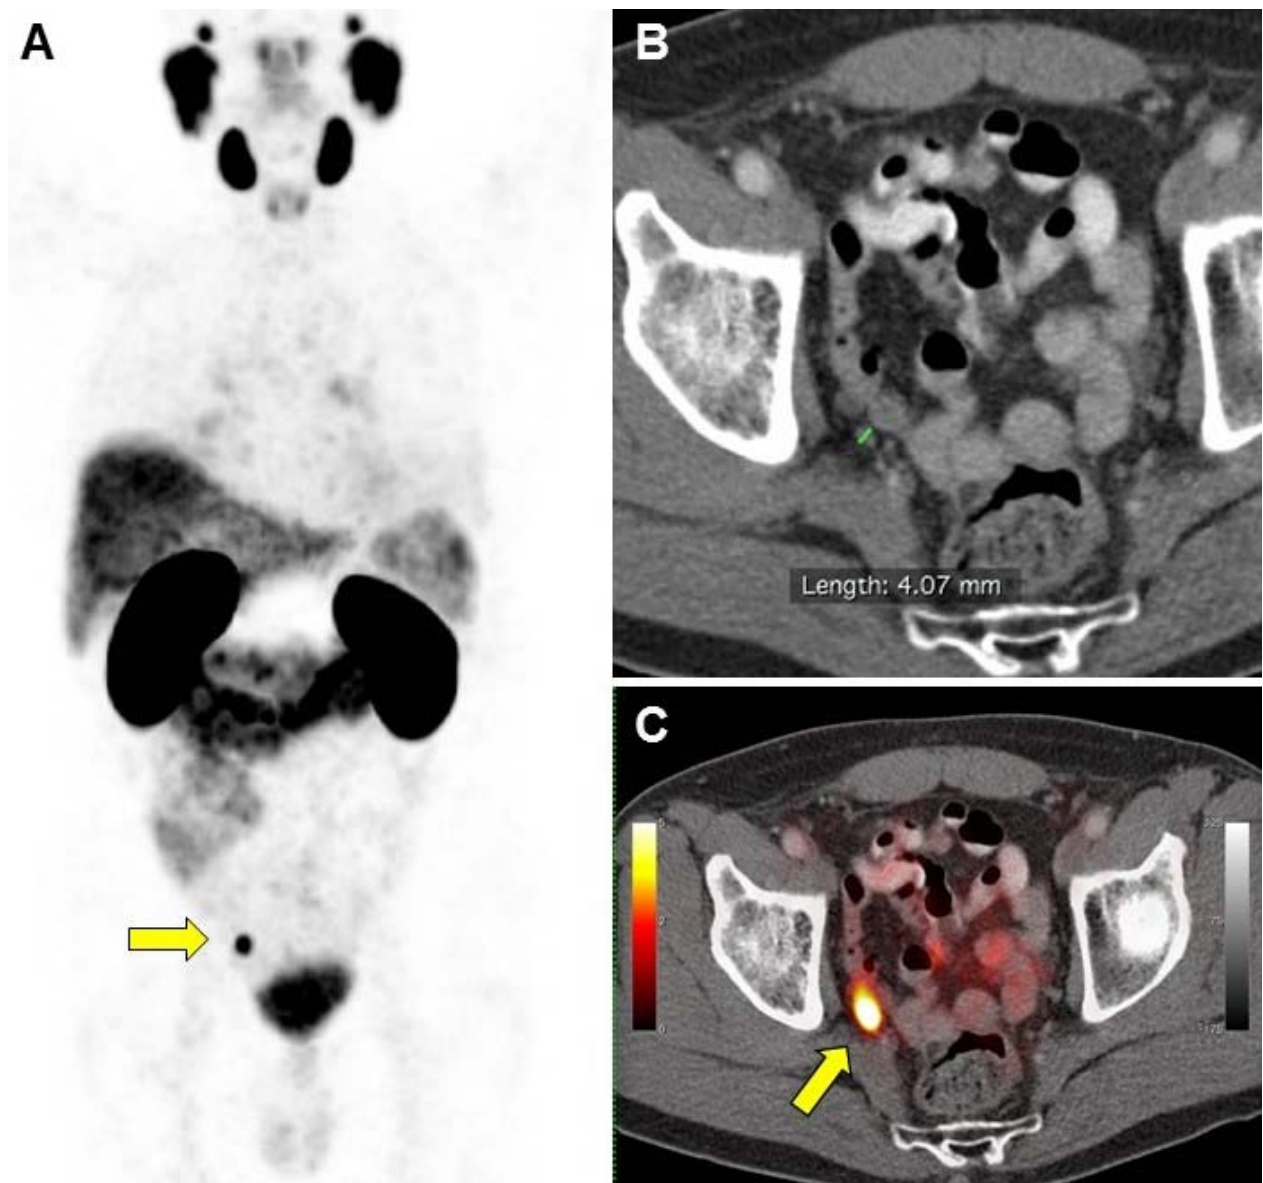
PSMA-11 PET/CT scan in a 70-year-old man with BCR (PSA 1.06 ng/ml, doubling time 7 months) of an initially high-risk prostate cancer (Gleason 8, pT2c) one year after primary radical prostatectomy. Intended treatment before PSMA-11 PET/CT was active surveillance (Q1). PSMA-11 PET/CT showed intense PSMA-11 uptake (SUVmax 10.8) in a 4 mm right internal iliac pelvic lymph node (yellow arrows). Intended treatment after PSMA-11 PET/CT (Q2) was surgery. The intended change was
